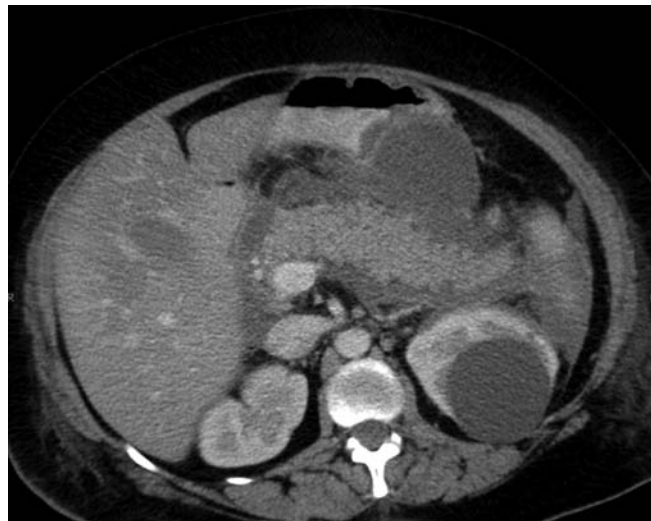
An abdominal computed tomography scan showing a diffuse enlargement of the pancreas, densification of the peripancreatic fat and 2 free fluid collections.
